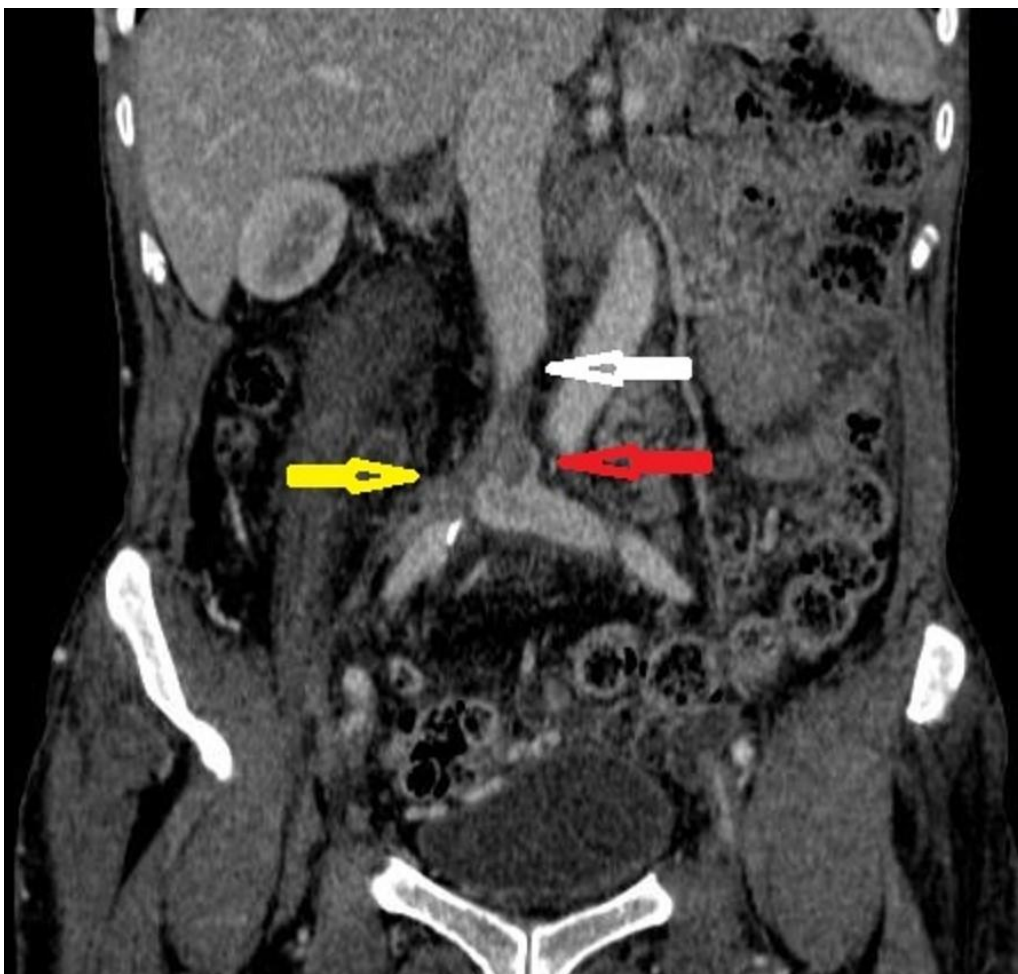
Coronal CT scan showing complete thrombosis of right common iliac vein (yellow arrow), near total thrombosis of inferior vena cava (white arrow) and partial thrombosis of left common iliac vein (red arrow)
